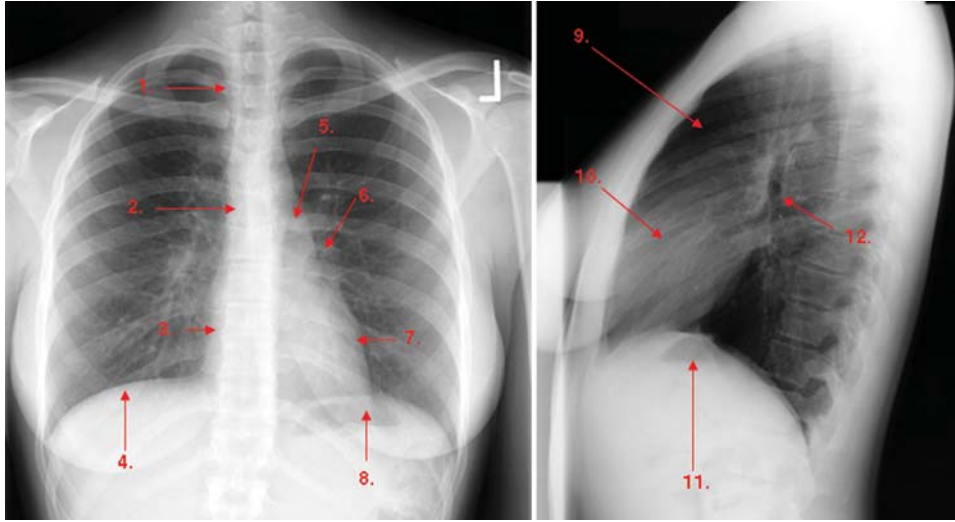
FIGURE e24-1 Normal chest radiograph—review of anatomy. 1. Trachea. 2. Carina. 3. Right atrium. 4. Right hemidiaphragm. 5. Aortic knob. 6. Left hilum. 7. Left ventricle. 8. Left hemidiaphragm (with stomach bubble). 9. Retrosternal clear space. 10. Right ventricle. 11. Left hemidiaphragm (with stomach bubble). 12. Left upper lobe bronchus.
